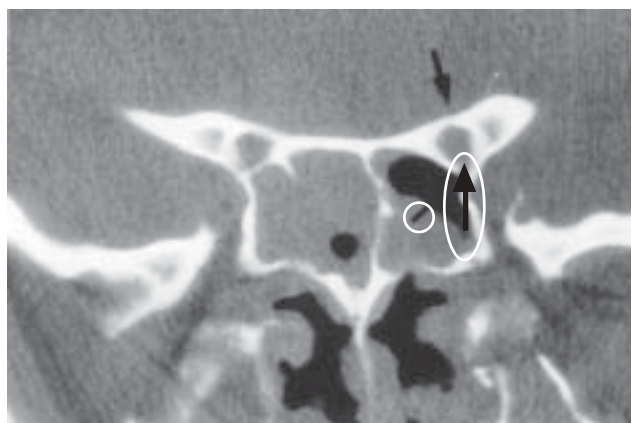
A computed tomography (CT) scan demonstrating a fracture of the optic canal (arrows). CT scan: Courtesy of Department of Ophthalmology, Allegheny General Hospital, Pittsburgh, Pa.
